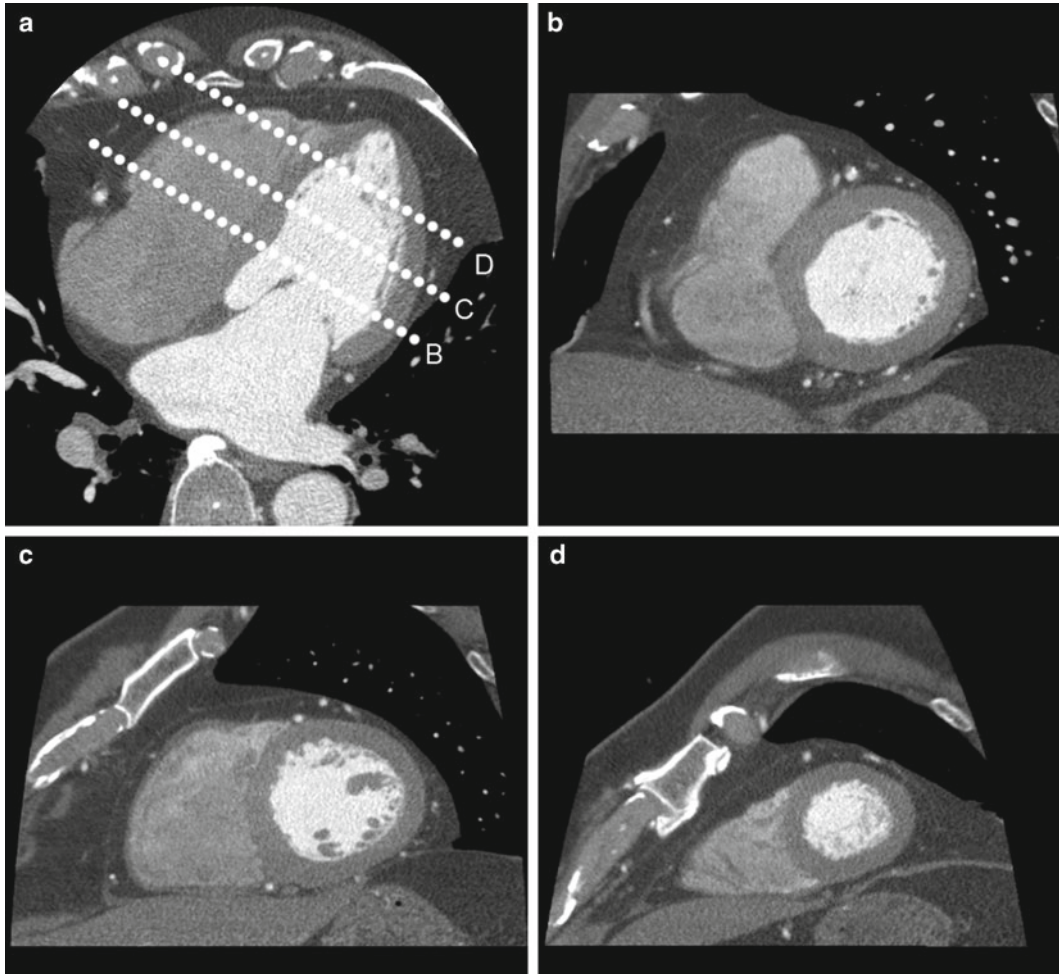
Multiplanar reconstructions of multidetector computed tomographic images of epicardial adipose tissue. Multiplanar reconstructions of multidetector computed tomographic images in the horizontal long-axis (a) and short-axis (b–d) planes are shown. Anatomical landmarks for the selection of the basal (b, tips of the mitral valve leaflets), mid-cavity (c, papillary muscles), and apical (d, beyond the papillary muscles but before the end of the cavity) short-axis slices are displayed. The horizontal long- and short-axis planes are at 90° relative to the long-axis of the left ventricle
